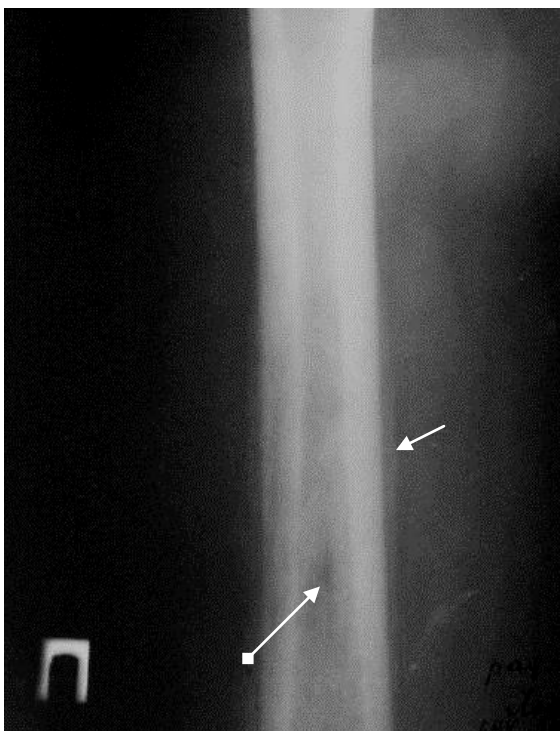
The radiograph of the right femur in a direct projection. In diaphysis area single layer periosteal reaction is defined (arrow). Sites of destruction are in the field of diaphysis (arrow with rhombus). Radiological symptoms of acute osteomyelitis
